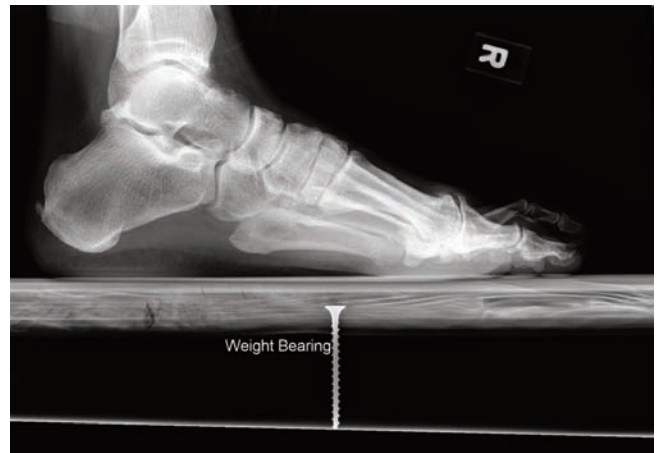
Preoperative lateral radiograph.
